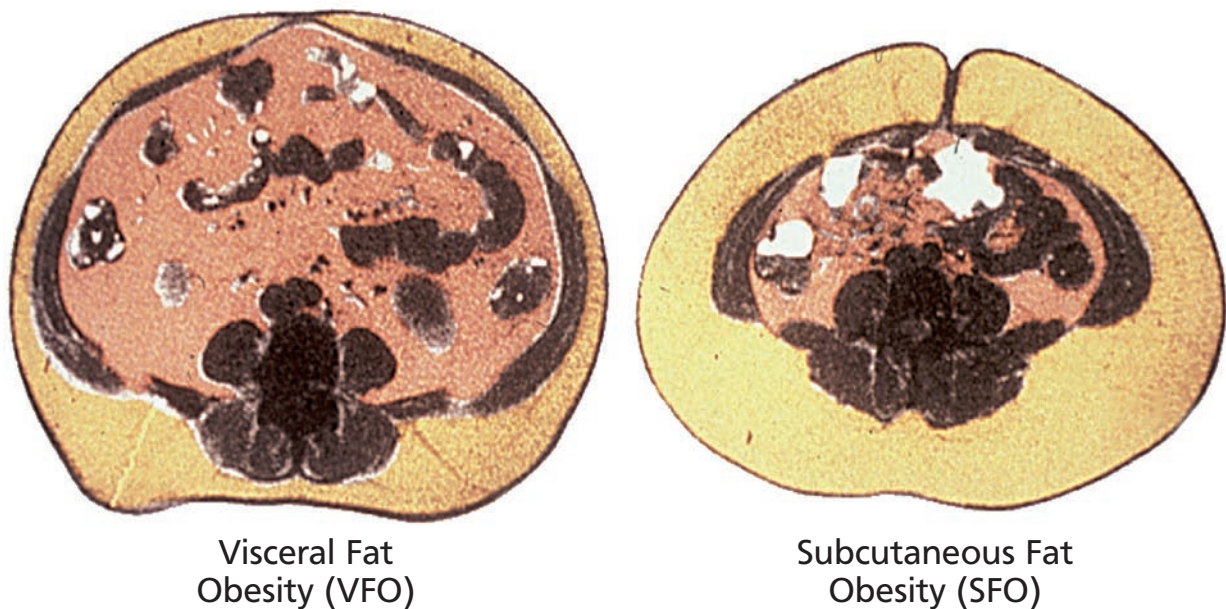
Visceral fat type obesity (VFO) and subcutaneous fat type obesity (SFO) are assessed by computed tomography (CT) at umbilicus level. VFO is more associated with various obesity-related complications, such as insulin resistance, diabetes, dyslipidemia, hypertension, and coronary artery disease, than SFO.
